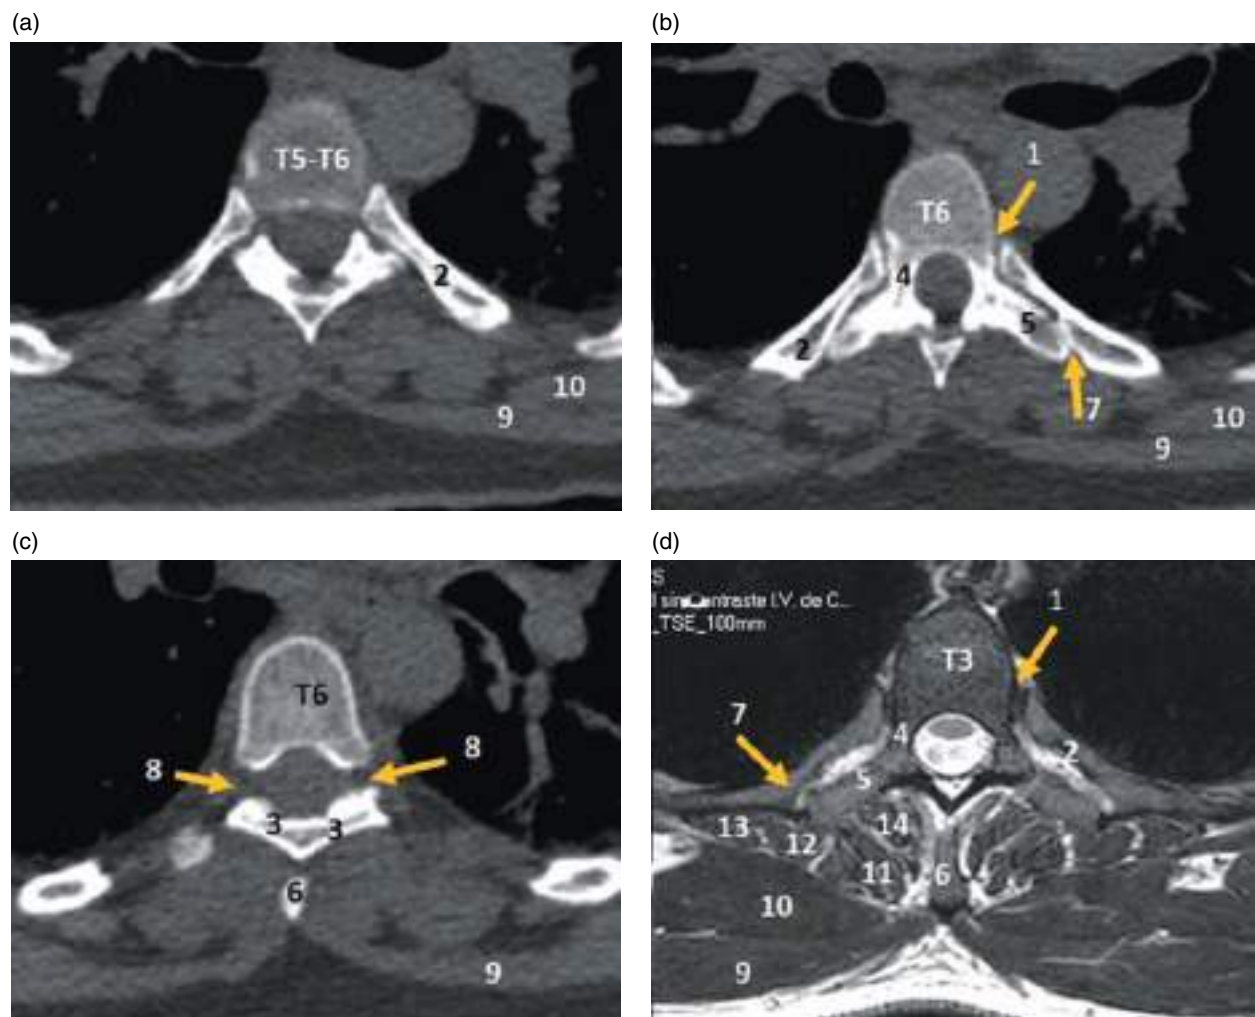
Axial CT image at the level of the T5–T6 disc (a), T6 pedicles (b), and T6 foramen (c). (d) Axial T2-weighted MRI at the level of T3. 1, costovertebral joint; 2, rib; 3, lamina; 4, pedicle; 5, transverse process; 6, spinous process; 7, costotransverse joint; 8, vertebral foramen; 9, trapezius muscle; 10, rhomboid major muscle; 11, spinalis thoracis muscle; 12, longissimus muscle; 13, iliocostalis muscle; 14, transversospinalis muscles.
